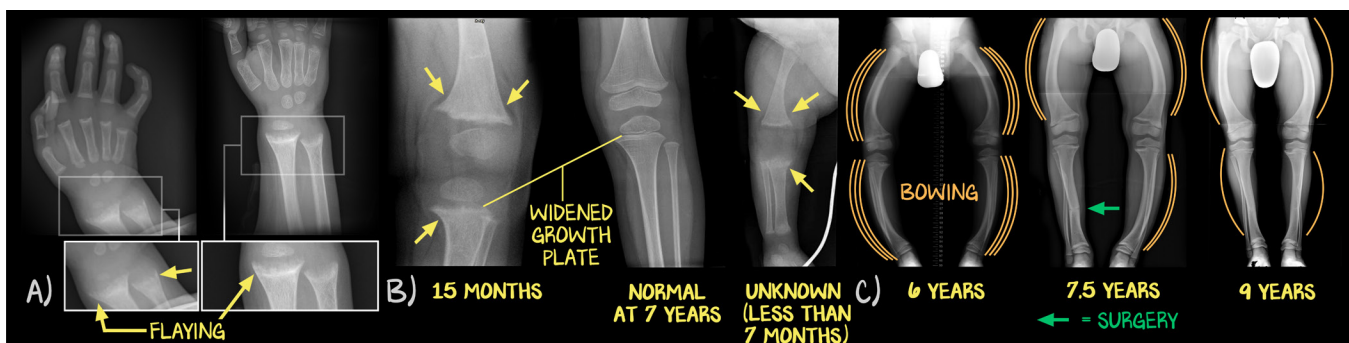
Radiographic Rickets
